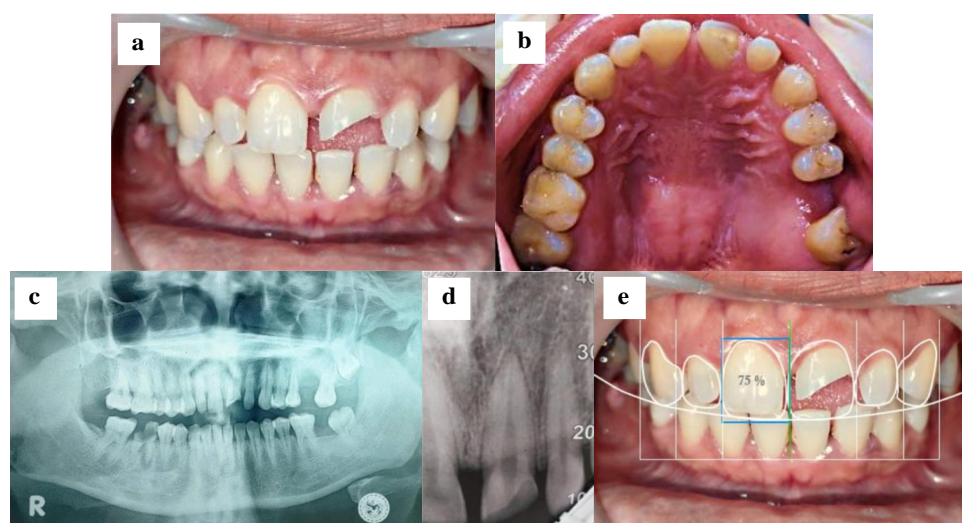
Pre-treatment condition: Clinical frontal view (a); Clinical occlusal view (b); Panoramic radiograph (c); Periapical radiograph (d); Digital smile design (e).
